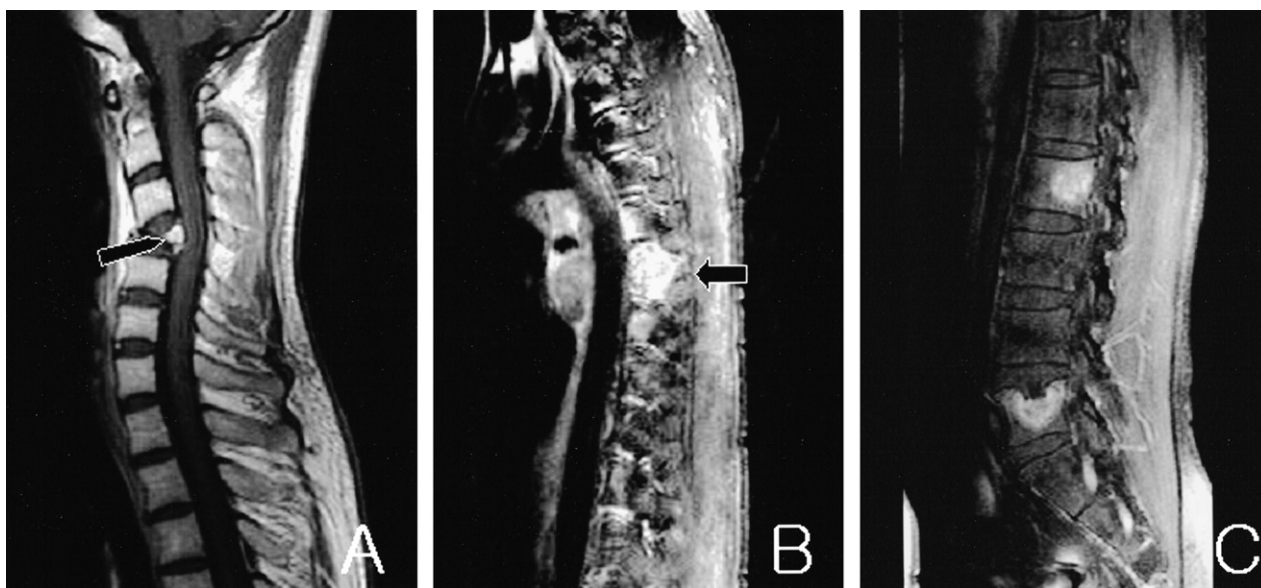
(A) Sagittal gadolinium-enhanced cervical spine MRI showing that the C4 body (arrow) is severely collapsed, displacing it posteriorly and compressing the spinal cord. (B) Sagittal gadolinium-enhanced thoracic MRI shows strong enhancement of the T6 vertebral body (arrow). (C) Sagittal gadolinium-enhanced lumbar MRI reveals localized enhancement in the L2 and L5 vertebral bodies.
